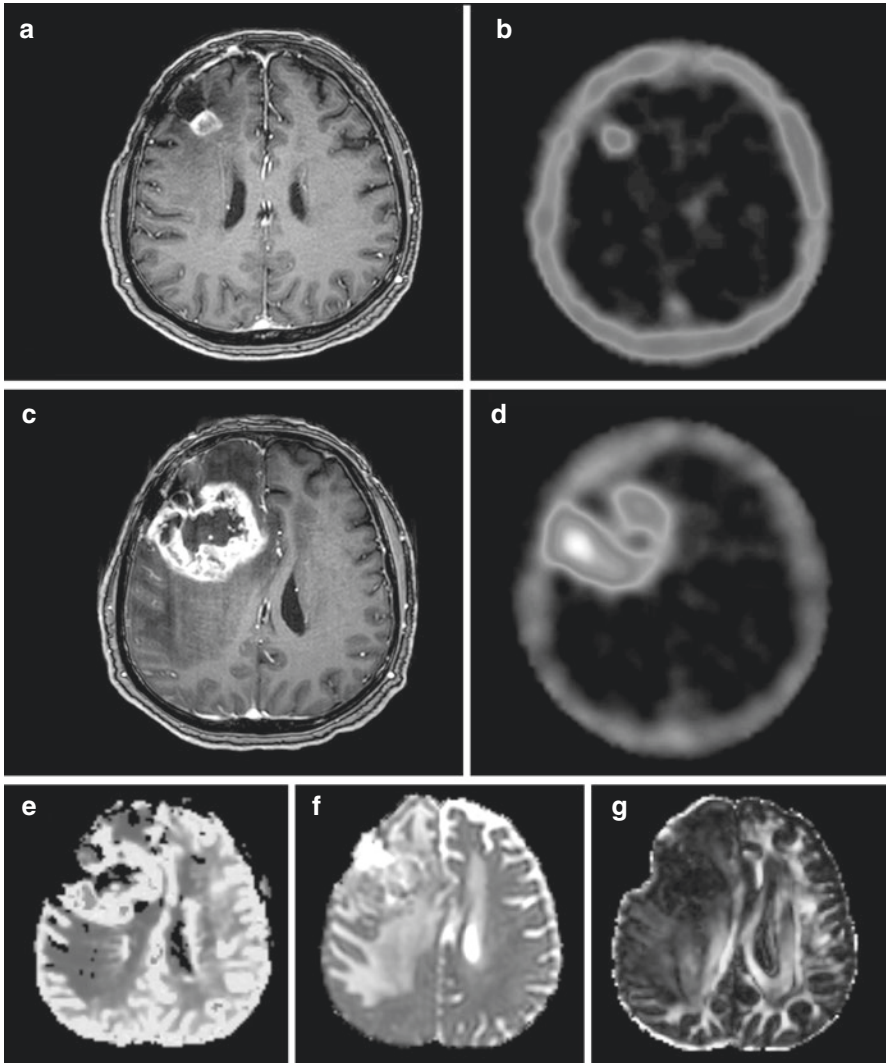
A 66-year-old male with glioblastoma of the right frontal lobe diagnosed 21 months earlier and treated by surgery and radiochemotherapy (temozolomide). (a) Gadolinium-enhanced T1-weighted MRI revealed a postsurgical cavity with an adjacent enhancing dense area that raised the question of tumor recurrence versus radiation necrosis. (b) A few days later, ^{99m}Tc -tetrofosmin SPECT revealed intense tracer uptake (tumor-to-background ratio [TBR] = 11) in the corresponding area of gadolinium enhancement suggesting recurrence. (c) Eight months later—a new surgery in the meantime verified recurrent glioblastoma—Gd-T1w MRI revealed tumor progression. (d) The corresponding SPECT image at the time was also typical of tumor progression (TBR > 20) with a central photopenic necrotic area. (e) Further investigation by advanced MRI techniques showed an increased relative cerebral blood volume (rCBV) in the corresponding areas of profound radiotracer uptake, indicating intense angiogenesis. (f) The apparent diffusion coefficient (ADC) map showed highly irregular water diffusivity throughout the lesion that was surrounded by extensive edema. (g) Diffusion tensor imaging (DTI) with fractional anisotropy (FA) mapping revealed abrupt white matter fiber disruption by the lesion consistent with a high-grade recurrent tumor
